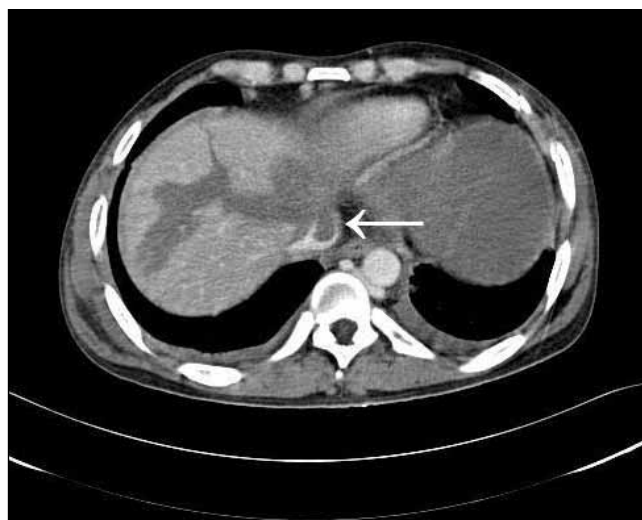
Contrast-enhanced CT scan through the upper abdomen shows laceration of the anterior wall of the IVC with intraluminal thrombosis (arrow).
